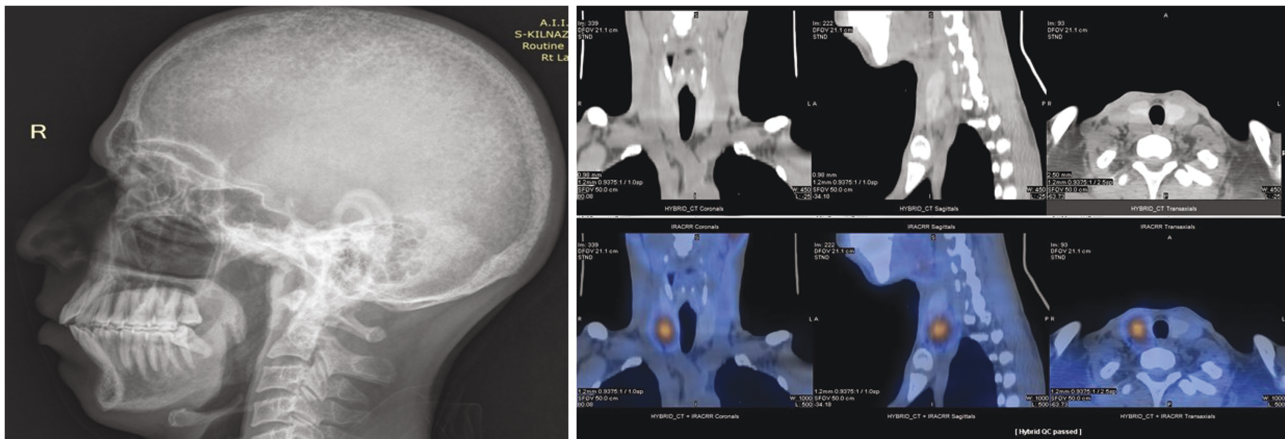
A, X-ray of the skull right lateral view showing classical “salt and pepper” appearance. B and C, Single-photon emission computed tomography (SPECT)-CT imaging of the neck showing a radiotracer avid well circumscribed soft tissue density lesion $1.8 \times 2.0 \times 3.6$ cm, lying posterior and medial to the inferior pole of right lobe of thyroid gland suggestive of single right inferior parathyroid adenoma.
